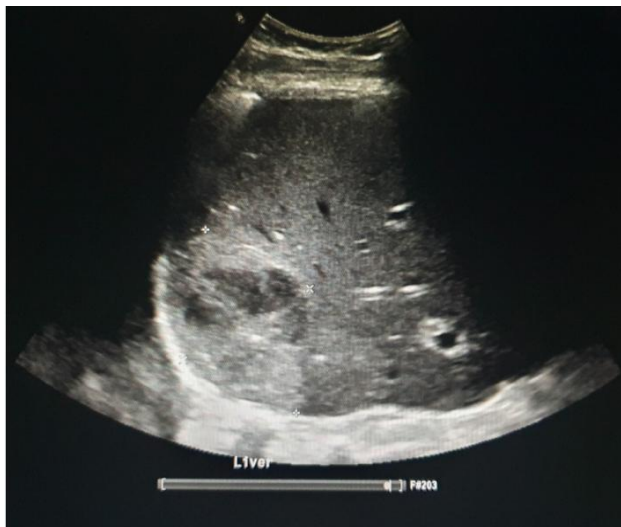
Ultrasound scan of the liver shows a 7.8cm x 5.7cm abscess
